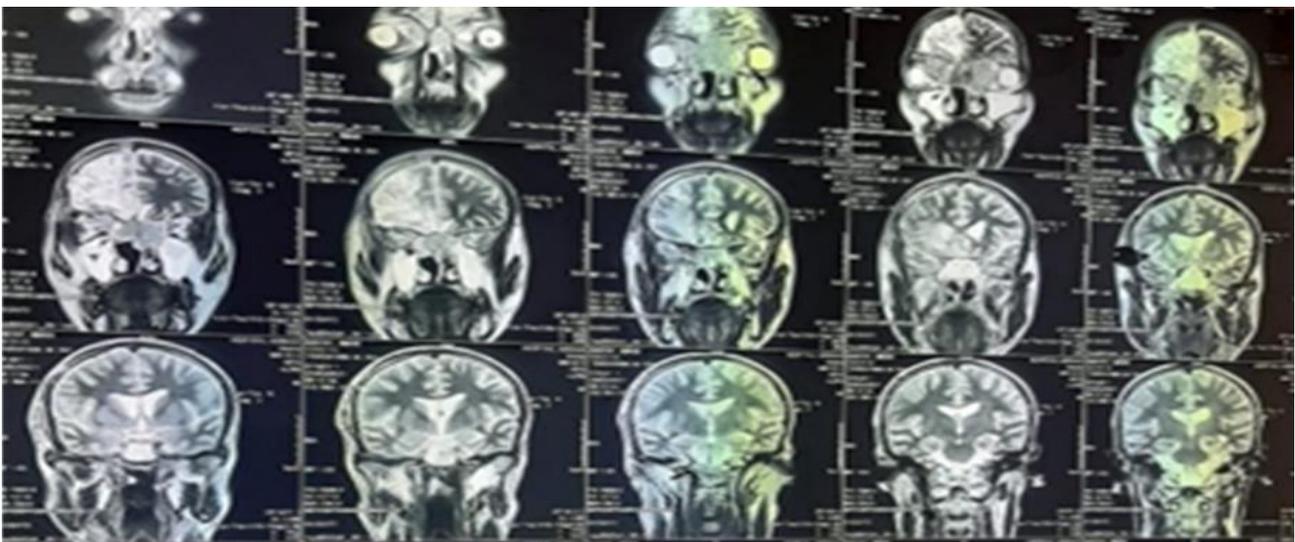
Postoperative craniocervical MRI frontal section T2 sequence
